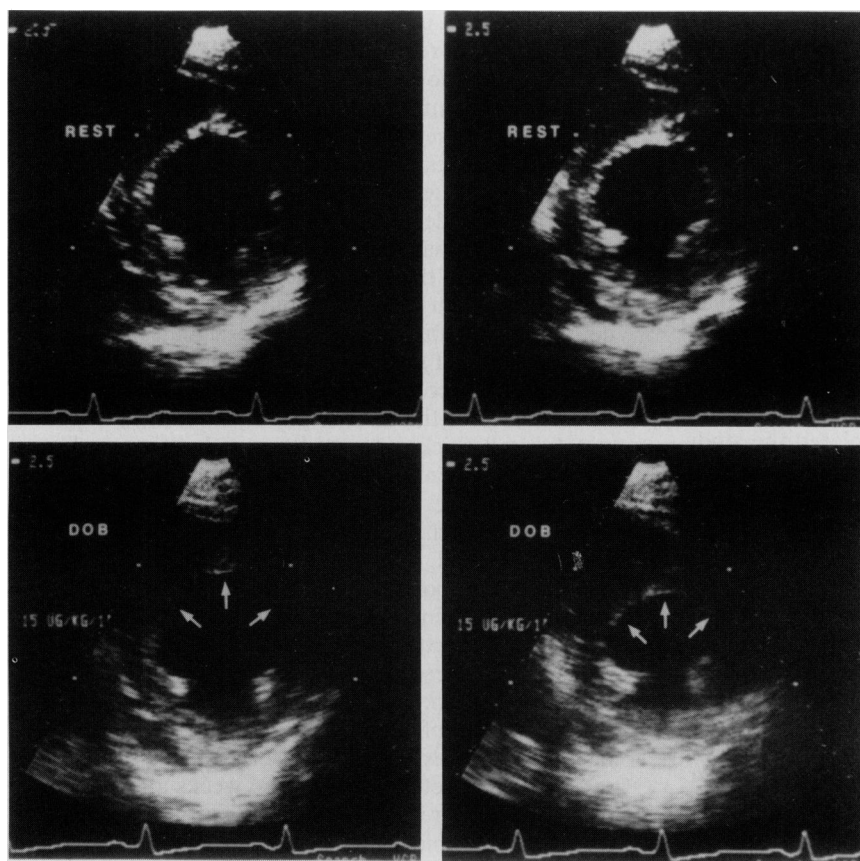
Representative example of contractile reserve as demonstrated by dobutamine stress echocardiography in a patient in this study. Top panels show resting midventricular short-axis frames at end diastole (left) and end systole (right). Marked hypokinesis is present in septal, anterior, and anterolateral segments. Bottom panels show the same views after dobutamine infusion ($15 \mu\text{g} \cdot \text{kg}^{-1} \cdot \text{min}^{-1}$) at end diastole (left) and end systole (right). As shown by the arrows, dobutamine resulted in a marked improvement in regional contractile function.
